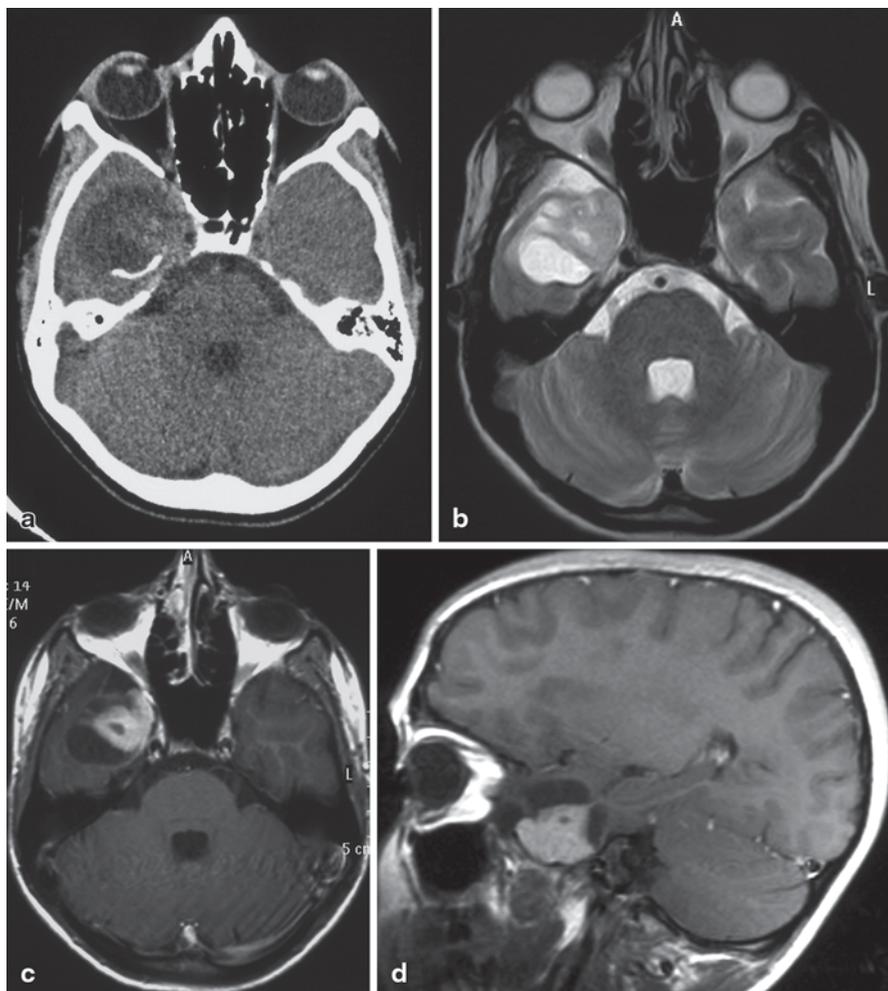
GG in a 10-year-old girl. a Axial CT scan. b Axial T2-weighted image. c Axial Gd-enhanced T1-weighted image. d Sagittal Gd-enhanced T1-weighted image. CT shows an heterogeneous, prevalingly hypodense, mass lesion in the right temporal pole with gross, shell-like calcifications (a). The tumor has a cortical location and cystic and solid appearance (b). The solid component is mildly hyperintense on T2-weighted image (b) with marked enhancement following gadolinium injection (c, d)
